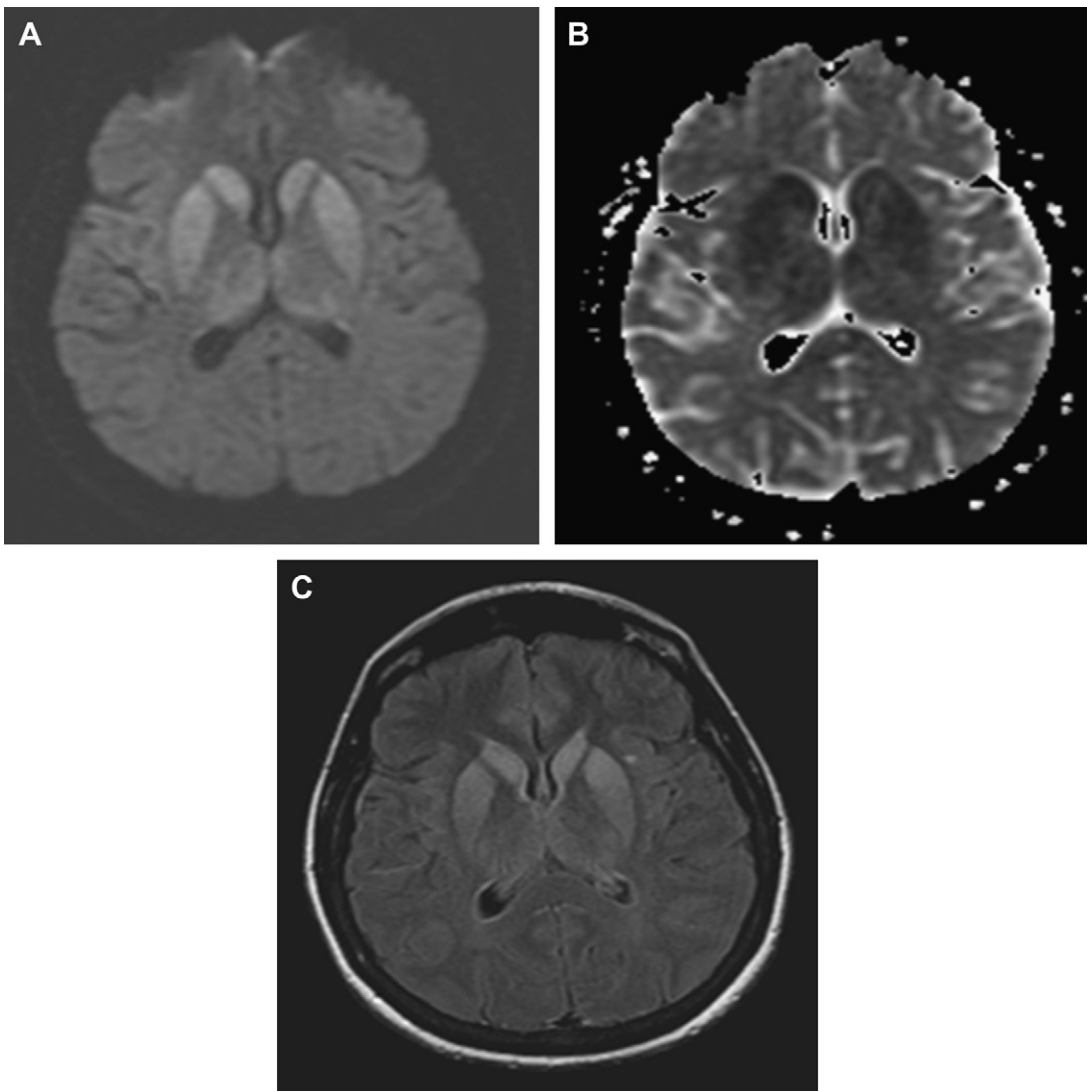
Creutzfeldt-Jakob disease. MR diffusion-weighted (A), ADC map (B), and FLAIR (C) images. True restricted diffusion involving the basal ganglia and thalamus (pulvinar) are noted.
